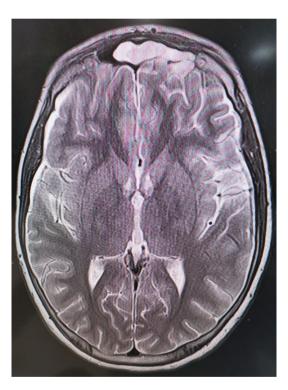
MRI brain with contrast during the follow up after 3 weeks
